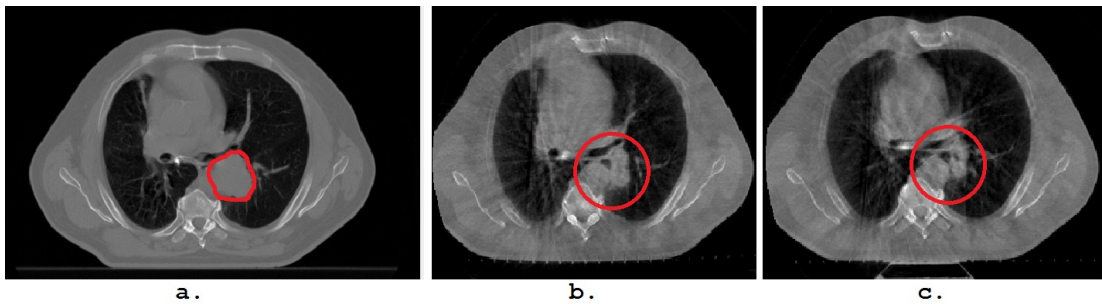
Mapping of the GTV over the course of treatment: a. single slice of the planning-CT along the red contour for GTV boundry, b. CBCT #1 acquired before any radiotherapy is given(thirteen days after the planning CT) and c. the CBCT #10, 26 days after the initial planning CT.
